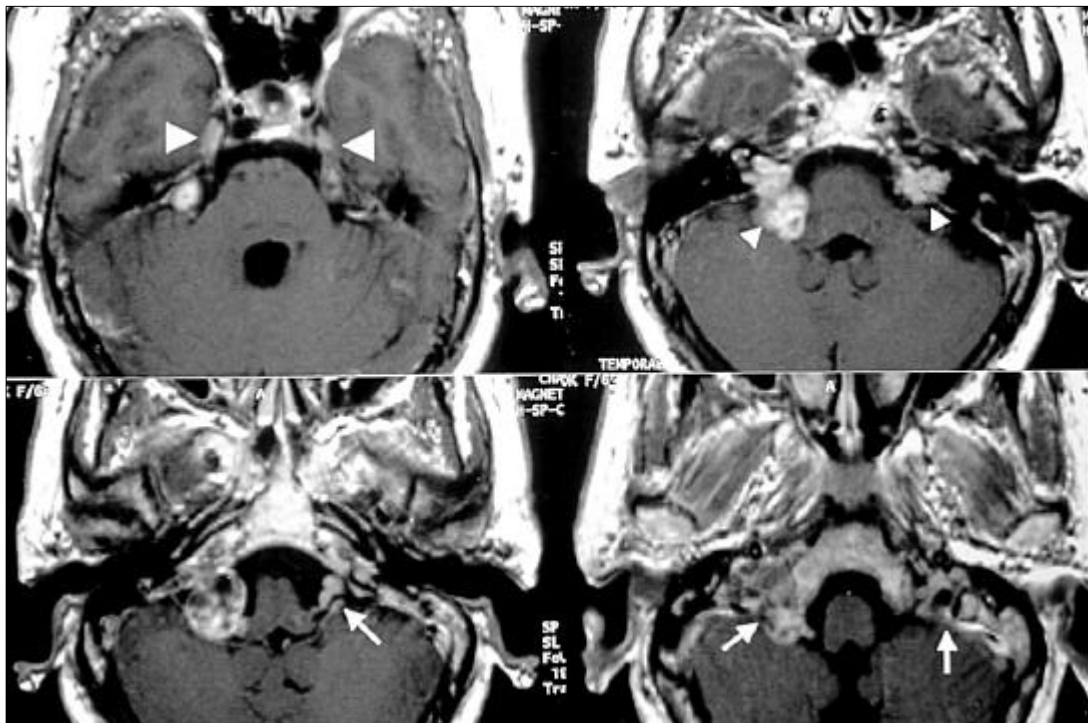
Axial magnetic resonance imaging of the brain revealing multiple lesions in the bilateral cerebellopontine angles. The masses originated from the bilateral trigeminal (large arrowhead), acoustic (small arrowhead), and lower cranial nerves (arrow). The masses of the lower cranial nerve complex extend to the jugular fossa.
